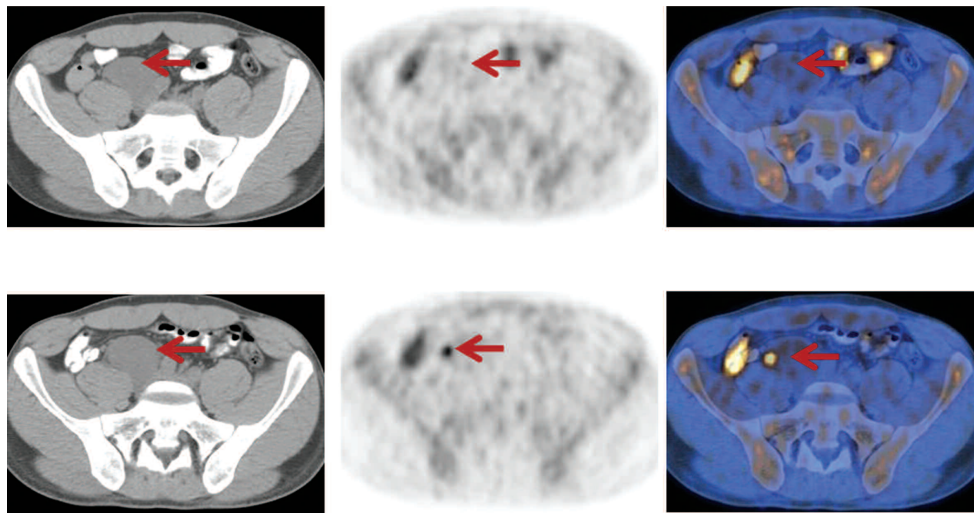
Patient with stage IIB abdominal HL (unfavorable) referred for a routine follow-up 6 months after completion of therapy, with no clinical symptoms. Post-completion PET/CT study (upper panel) shows a mass in the right common iliac region (arrows) with no appreciable FDG uptake consistent with treated lymphoma. However, the 6-month follow-up PET/CT study (lower panel) shows a focus of FDG uptake (arrows) within the mass, consistent with recurrent lymphoma.
